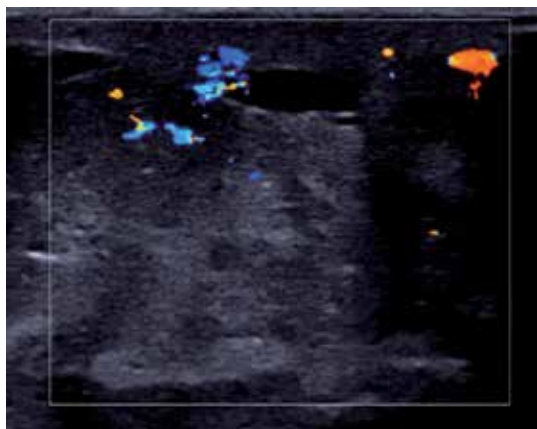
Increased color Doppler signal reflects the increase in vascularization after trauma.
